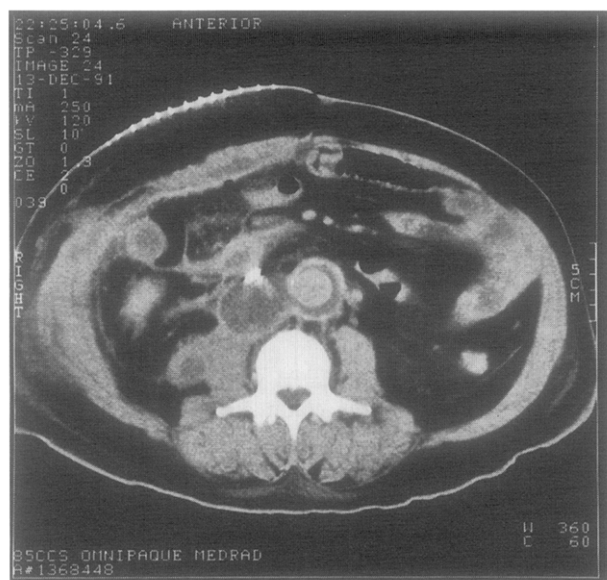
Computed tomography scan of aortic tube graft with surrounding right periaortic and right psoas fluid collections.
